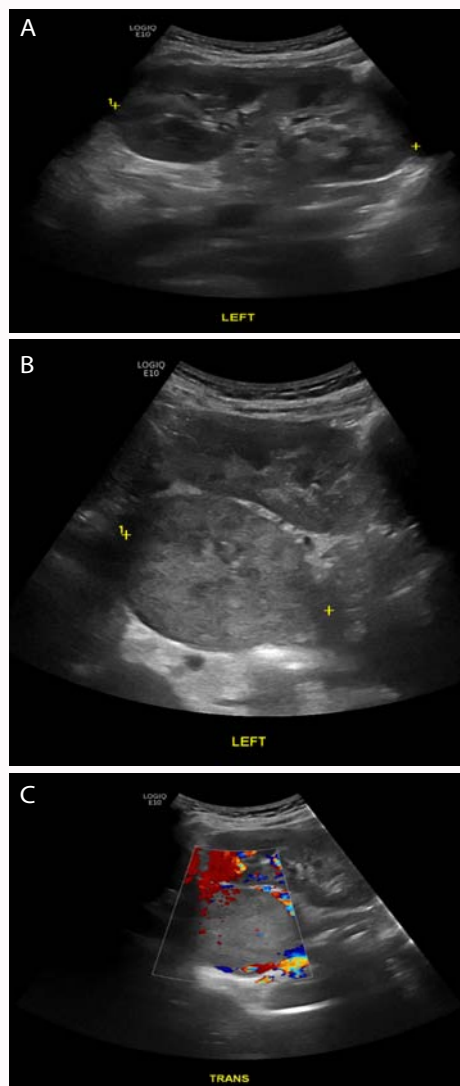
Abdominal ultrasound showing left adrenal tumor with a diameter of >8 cm (A); mixed cystic-solid components (B) and Doppler vascular imaging confirms the presence of vascular flow (C).
